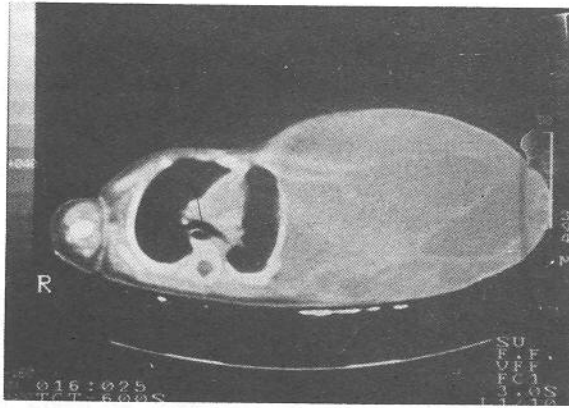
CT image of a giant lymphangioma case.
